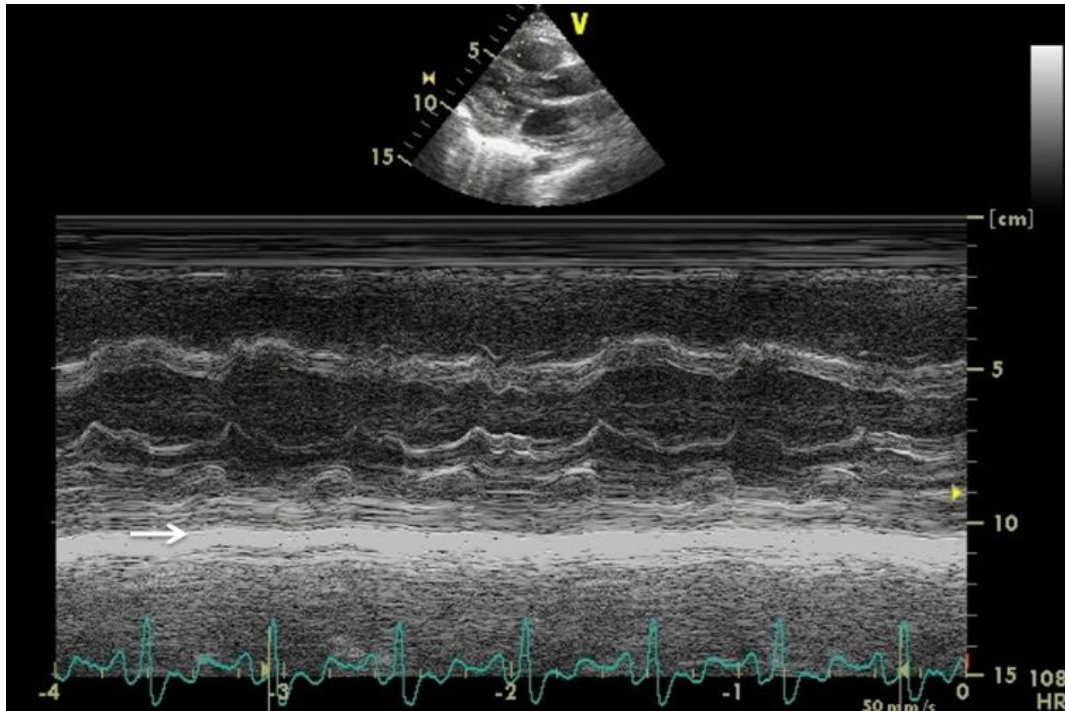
Figure legend 2: M-mode echocardiogram shows echo bright thickened posterior pericardium (white arrow).
